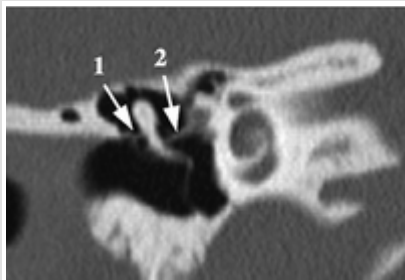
Coronal images reformatted from transverse multi-detector row CT images of a normal right temporal bone. Lateral malleal ligament (1) is shown, as well as tensor tympani tendon (2).
